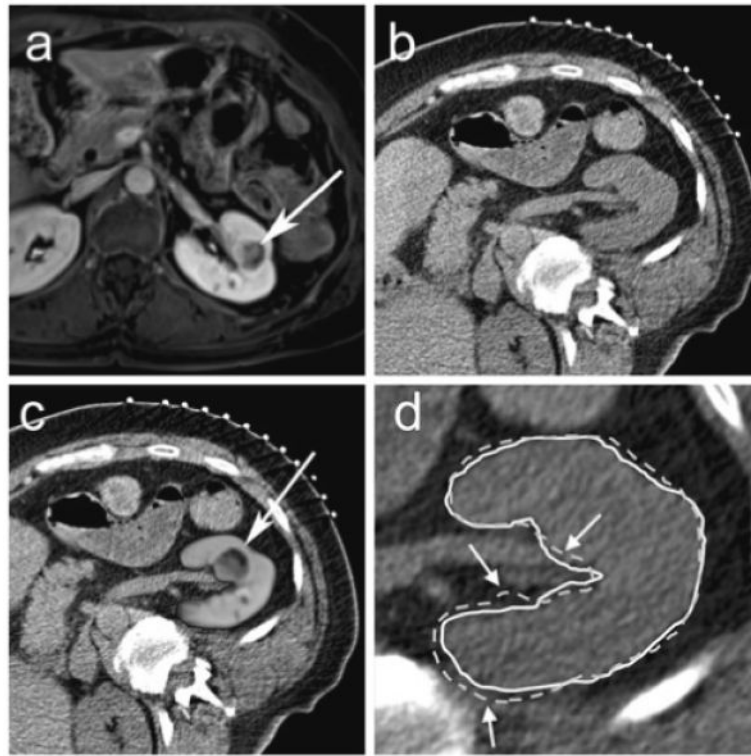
63-year-old female with left renal cell carcinoma. a Pre-procedural transverse contrast-enhanced spoiled gradient echo MR image of patient in supine position in a 1.5T scanner shows a 2.1 cm left renal mass (*arrow*). b Planning transverse unenhanced CT scan in the right posterior oblique position at the beginning of a CT-guided renal cryoablation shows the mass but the margins are not defined well. c MR image fused with CT image after non-rigid registration technique shows well-defined tumor in the left kidney (*arrow*). d The renal contour derived from registered MR images using non-rigid registration (*solid white line*) matches the renal contour on the CT image (*white arrows*) better than the renal contour derived from registered MR images using rigid registration (*dotted white line*)
